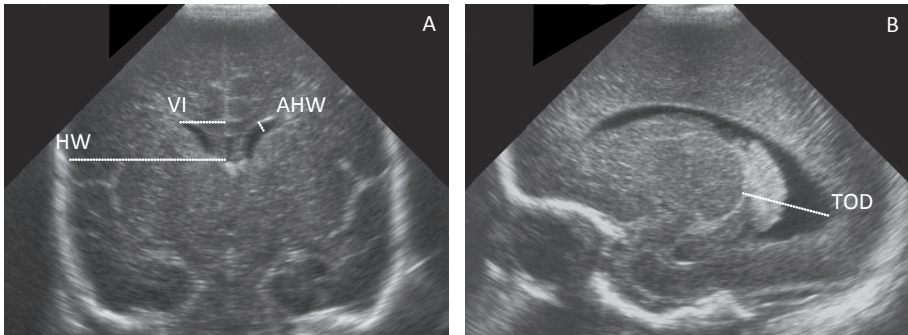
Measured ventricular parameters on cranial ultrasound (cUS) to diagnose post-haemorrhagic ventricular dilatation (PHVD).
